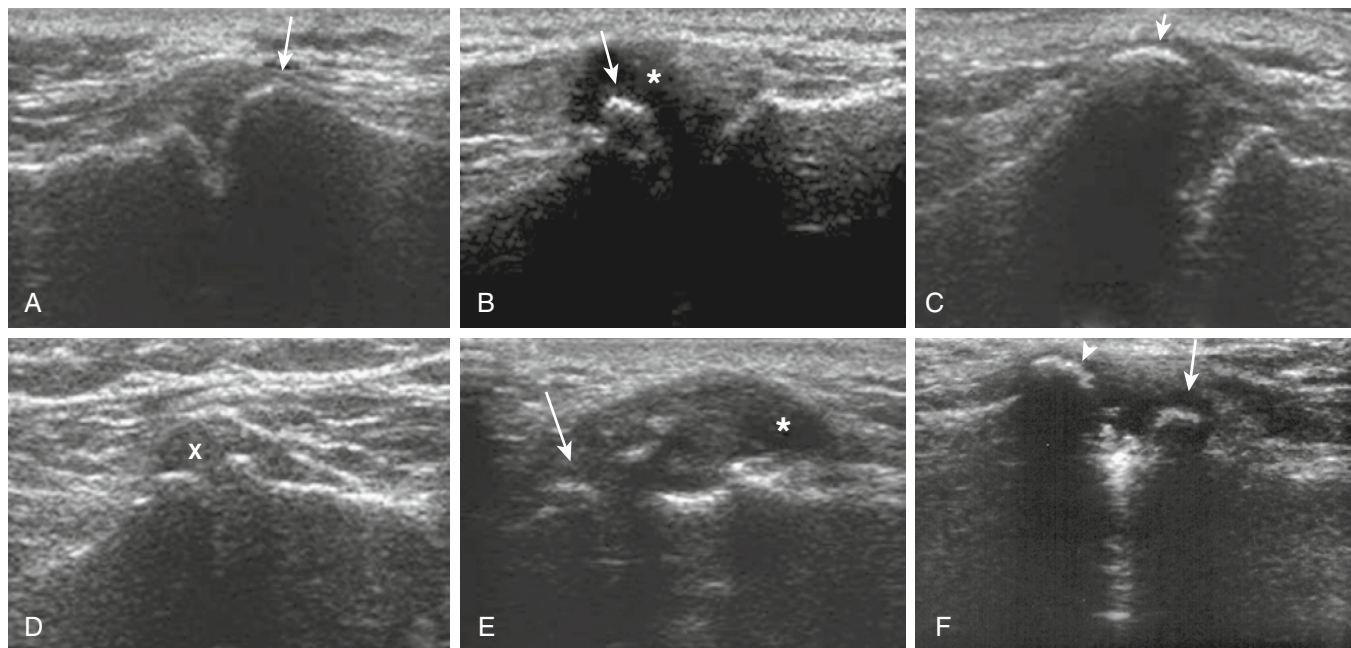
Ultrasound is used to assess an acromioclavicular joint with osteoarthritis. A-F, The 12-MHz longitudinal scan over the superior aspect of the joint shows various aspects of joint involvement, including osteophytes (*arrows*), joint subluxation (*arrowhead*), joint effusion (*stars*), and synovial thickening (*X*).
